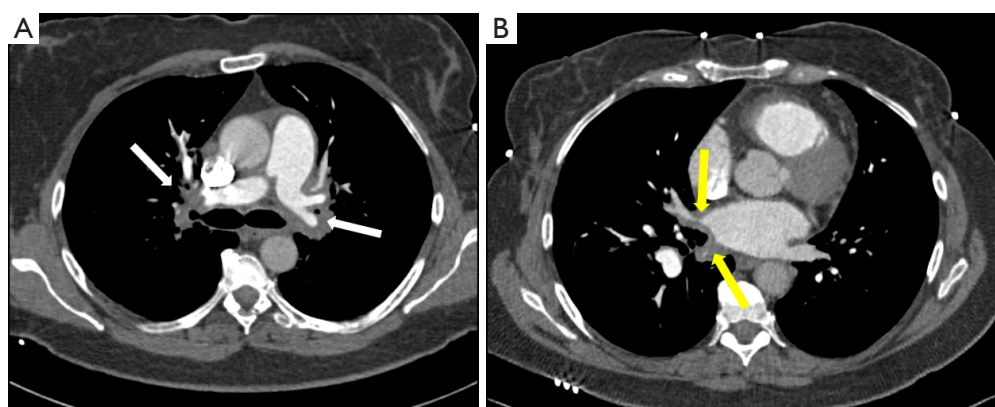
A 60-year-old woman with a known history of fibrosing mediastinitis. (A) Axial view chest CT scan showing diffuse mediastinal soft tissue thickening around the pulmonary artery (white arrows). (B) Axial view chest CT scan showing diffuse mediastinal soft tissue thickening around the pulmonary veins (yellow arrows). CT, computed tomography.
